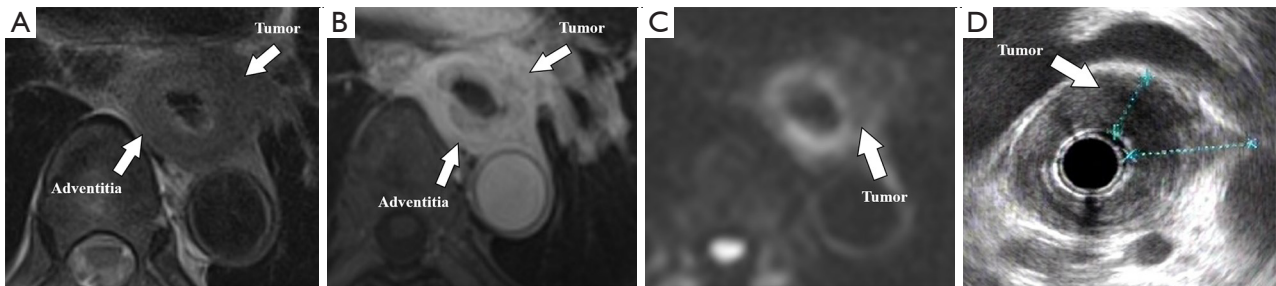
A 61-year-old male patient with T4 esophageal cancer: (A) T2WI BLADE, (B) enhanced T1WI StarVIBE, (C) DWI ($b = 800$), and (D) EUS. The tumor invades the pleura. T2WI, T2-weighted imaging; T1WI, T1-weighted imaging; StarVIBE, stack-of-stars volume interpolated breath-hold examination; DWI, diffusion-weighted imaging; EUS, endoscopic ultrasound.
